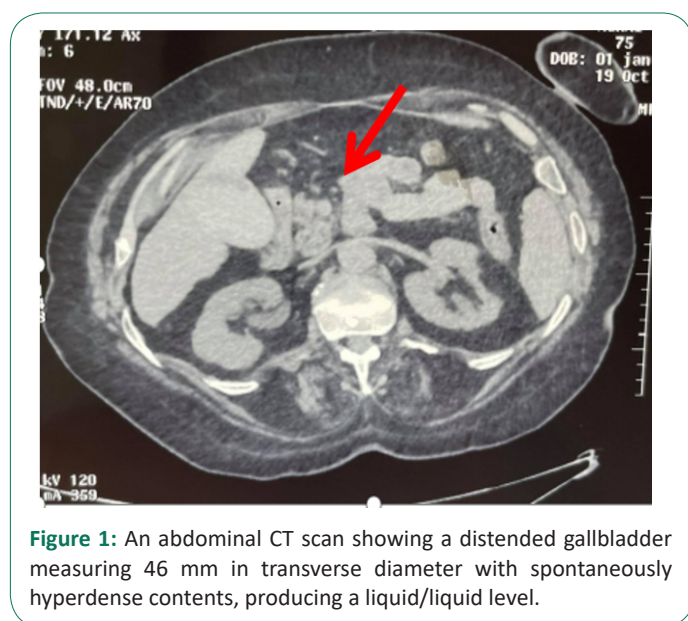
An abdominal CT scan showing a distended gallbladder measuring 46 mm in transverse diameter with spontaneously hyperdense contents, producing a liquid/liquid level.
